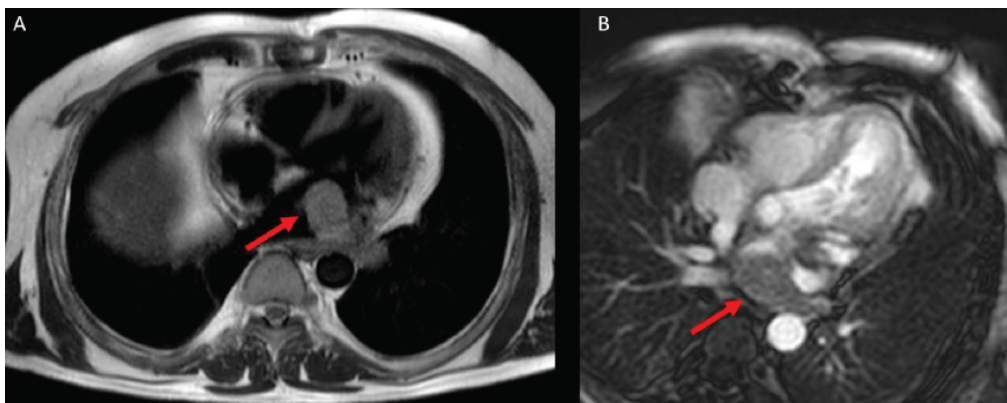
Pre-treatment MRI imaging (A) T1w axial showed left atrial involvement from sarcoma. (B) T1wCE+ showed involvement left pulmonary vein.
